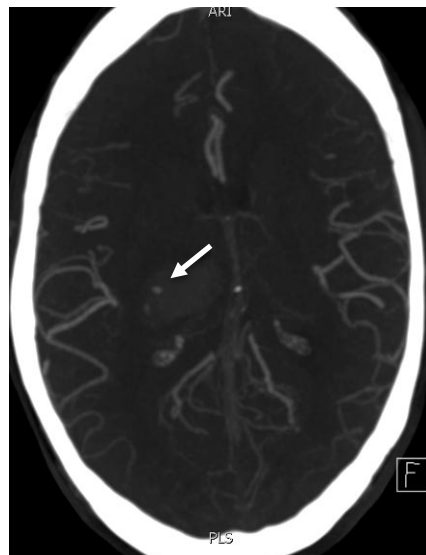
Brain CTA shows spot signs (arrow) indicating ongoing bleeding
